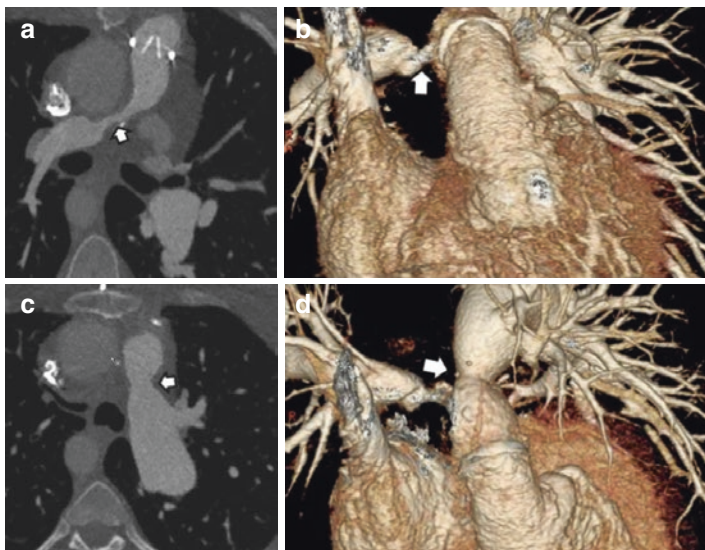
Computed tomography (CT) imaging of severe bilateral branch pulmonary stenosis in 27-year-old woman with history of truncus arteriosus status postoperative intervention in neonatal period. (a) Coronal images demonstrate severe narrowing of the main right pulmonary artery over a 2.1 cm-long segment (white arrow). The diameter of the narrowest area measures 4 mm. (b) Three-dimensional reconstruction shows the same severe narrowing of the main right PA (white arrow). (c) There is a focal narrowing at the origin of the left main PA to a diameter of 10 mm (white arrow), with poststenotic dilation of the left main PA. (d) Three-dimensional reconstruction of stenotic left main PA
